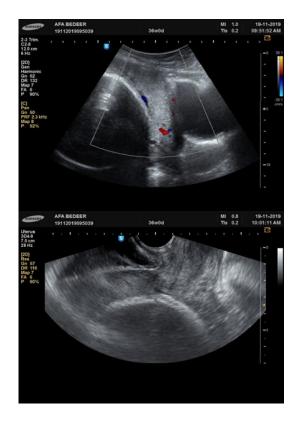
Ultrasound imaging of case 9
